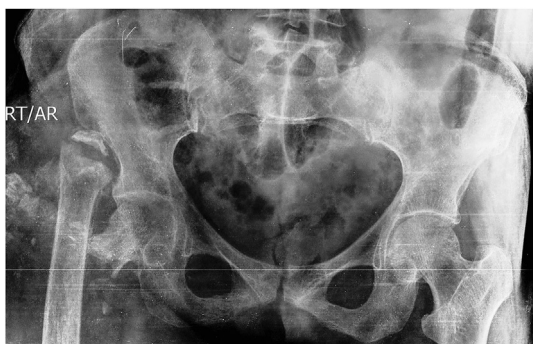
Plain AP radiograph of the pelvis showing a pathological fracture of the right proximal femur, with massive osteolysis.
